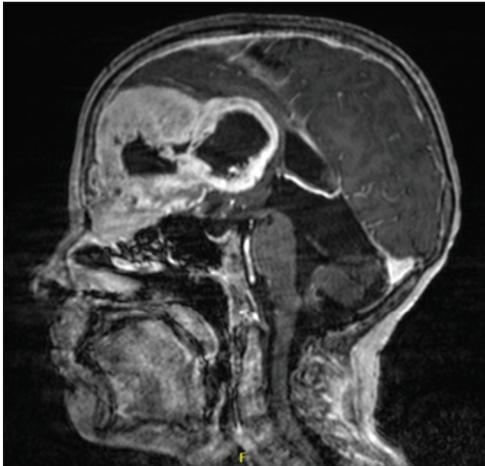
Sagittal magnetic resonance imaging with contrast showing a large mass centered on the left side of anterior cranial fossa/anterior falx with invasion of the skull base, medial left orbit, and left frontal sinus. There was notable erosion of the lamina papyracea on the left with extensive regional mass effect and effacement of the bilateral frontal horns and possible entrapment/developing hydrocephalus of the right occipital horn.
